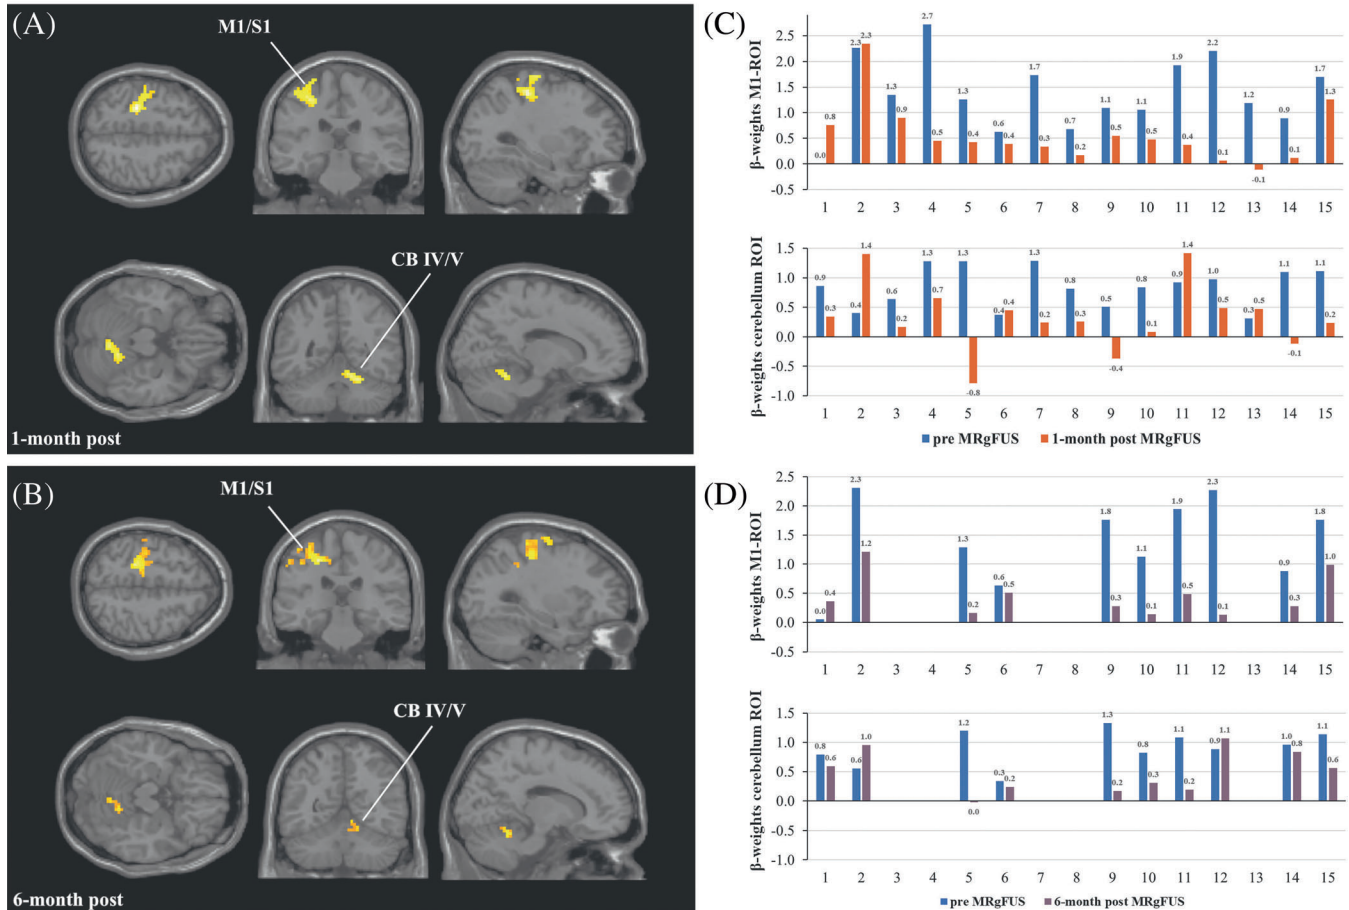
fMRI group analysis: reduced activation of contralateral sensorimotor cortex and ipsilateral cerebellum (left); visualization of β -weights extracted from M1-ROI and cerebellum-ROI (right); (A) contrast pre MRgFUS versus 1-month post MRgFUS; N = 15; (B) contrast pre MRgFUS versus 6-month post MRgFUS; N = 10; (C) β -weights pre MRgFUS versus 1-month post MRgFUS; N = 15; (D) β -weights pre MRgFUS versus 6-month post MRgFUS; N = 10. Abbreviations: CB, cerebellum; CB IV/CB V, cerebellar lobules IV and V; M1, primary motor cortex; ROI, region of interest, S1, primary sensory cortex; fMRI, functional magnetic resonance imaging; MRgFUS, magnetic resonance-guided focused ultrasound. [Color figure can be viewed at wileyonlinelibrary.com]
